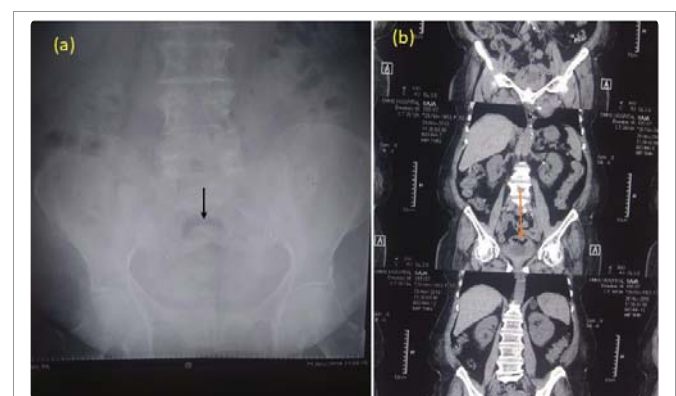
A plain radiograph (a) and a Computed Tomography (b) of Abdomen.
